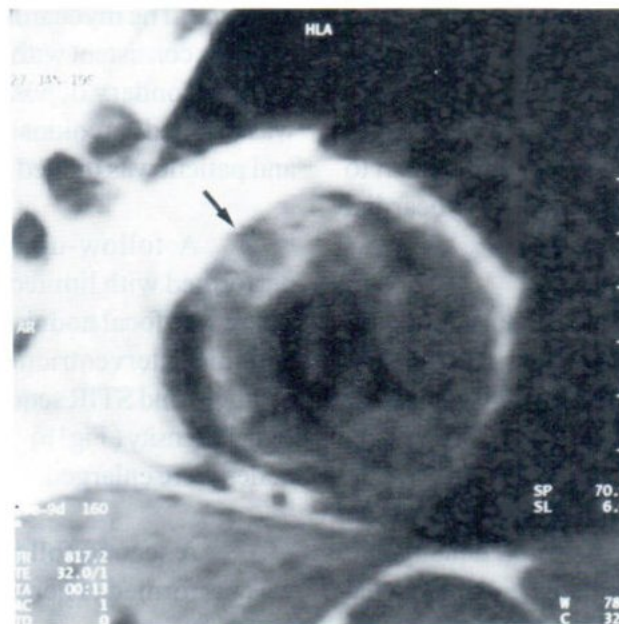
Follow-up short-axis T1-weighted fast spin-echo image reveal several hypointense nodular lesions with peripheral increase signal intensity in the interventricular septum (arrow)
